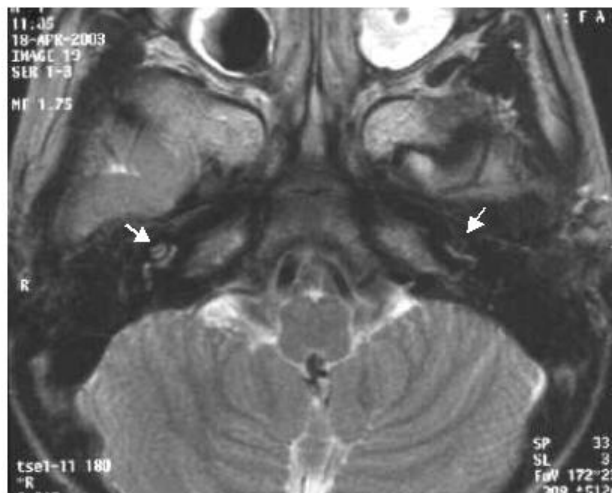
An axial T2-weighted MRI (case 2) shows hypointensity of the lumen of the cochlea bilaterally, compared to cerebrospinal fluid (CSF), which is hyperintense.
